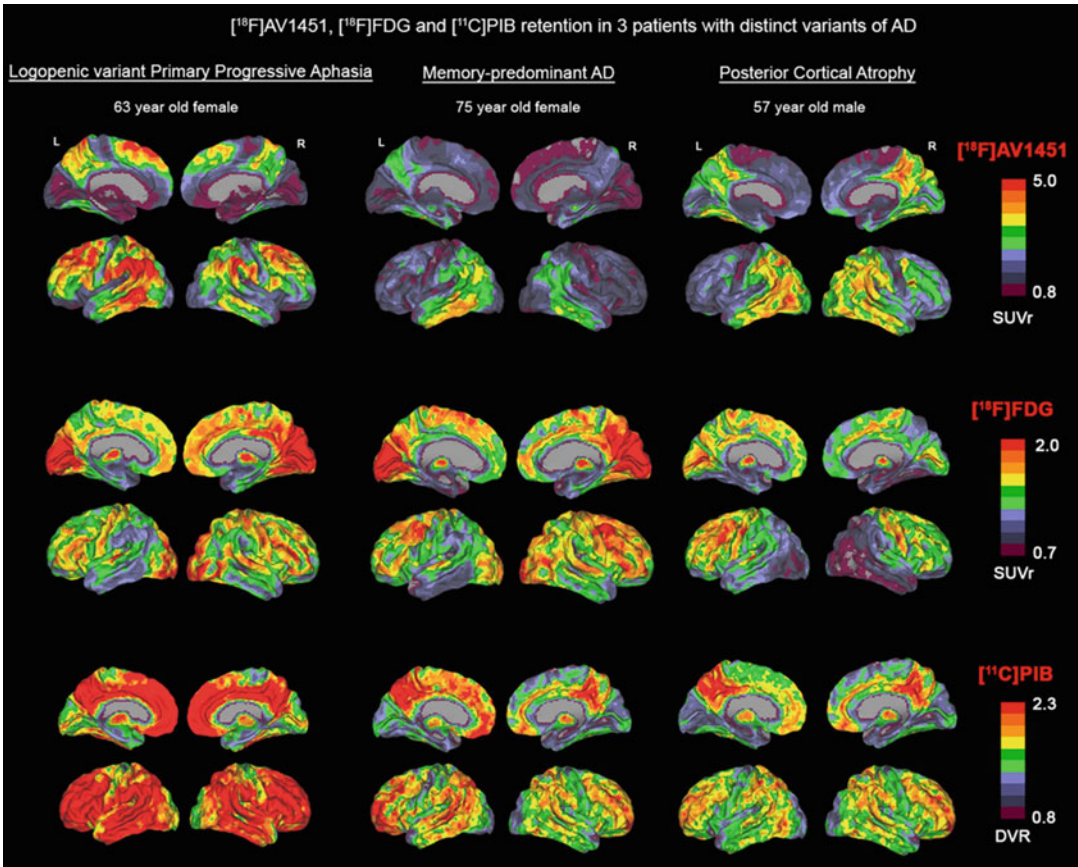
Three cases with distinct variants of Alzheimer's disease show Tau PET (AV1451) uptake in distinct brain regions (top row). A woman with PPA (left) shows an intense signal in language areas while her frontal and occipital areas are spared; a woman with mild typical AD (middle) appears to have tau pathology in the inferior temporal cortex; a man with posterior cortical atrophy (right) shows the strong signal in occipital and tempoparietal regions. Glucose (FDG) PET revealed
